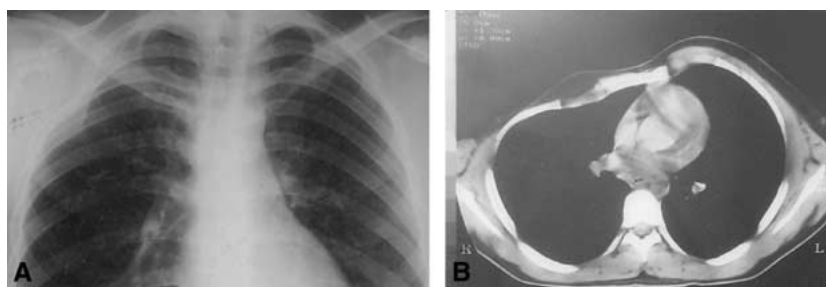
(A) Chest radiographic view of the patient. (B) CT view of the patient.
